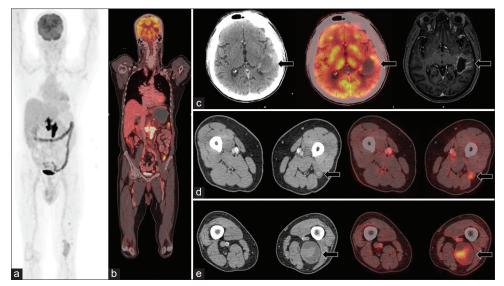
18F-FDG PET/CT (a) MIP image and (b) fused coronal image showing retroperitoneal nodal disease and intermuscular deposit in the left popliteal region. CT, Fused PET/CT and MRI (T1-weighted postcontrast) images showing (c) metastatic cystic brain lesion in the left temporal lobe with fluorodeoxyglucose avidity and enhancement along its periphery (arrow) (d) and (e) and fluorodeoxyglucose avid intermuscular deposits in the posterior compartment of the left thigh (arrow)
